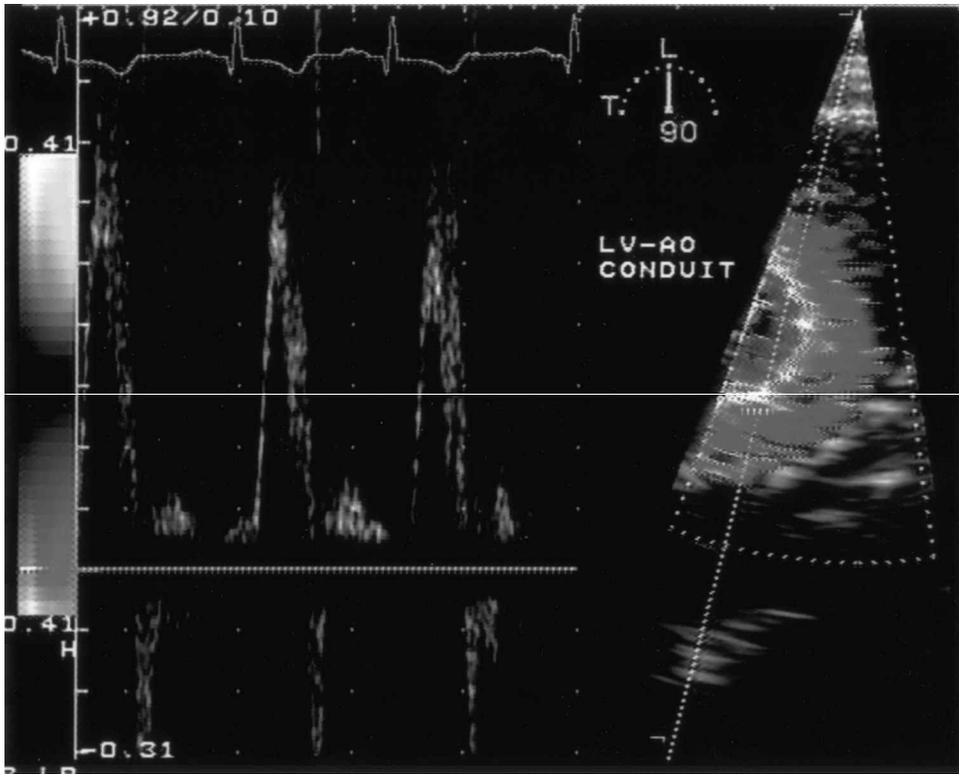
TEE at 90° with pulsed-wave and color-flow Doppler demonstrates laminar flow at the conduit-descending aorta junction.
